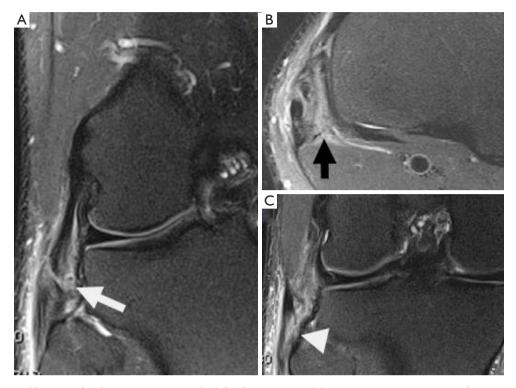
A 25-year-old man with a knee injury sustained while playing soccer. Magnetic resonance images in the coronal (A,C) and axial (B) planes with T2 weighted sequences with fat saturation. The images show high-grade injuries in the distal third of the lateral collateral ligament (white arrow) and in the distal biceps femoris tendon insertion (white arrowhead) and a capsuloligamentous injury of the posterolateral corner with popliteofibular ligament rupture (black arrow).
